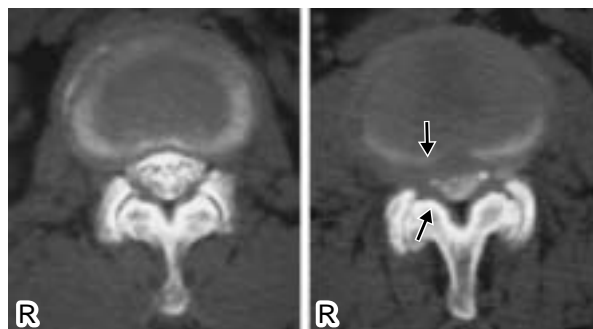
A case of nerve root-type intermittent claudication (myelography CT)
